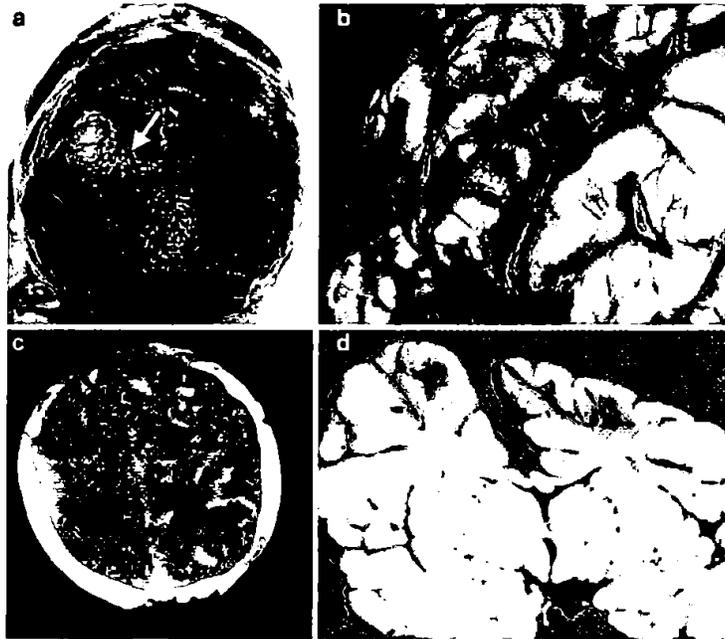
Subcortical clefts. a CT scan. Lateral view showing a fluid containing cyst in the immediate subcortical white matter. Infant 28 days old with pneumonia and no evidence of trauma. b The baby died a year later. Residual collapsed clefts are seen in the parasagittal subcortical white matter bilaterally. The cortex is almost completely
